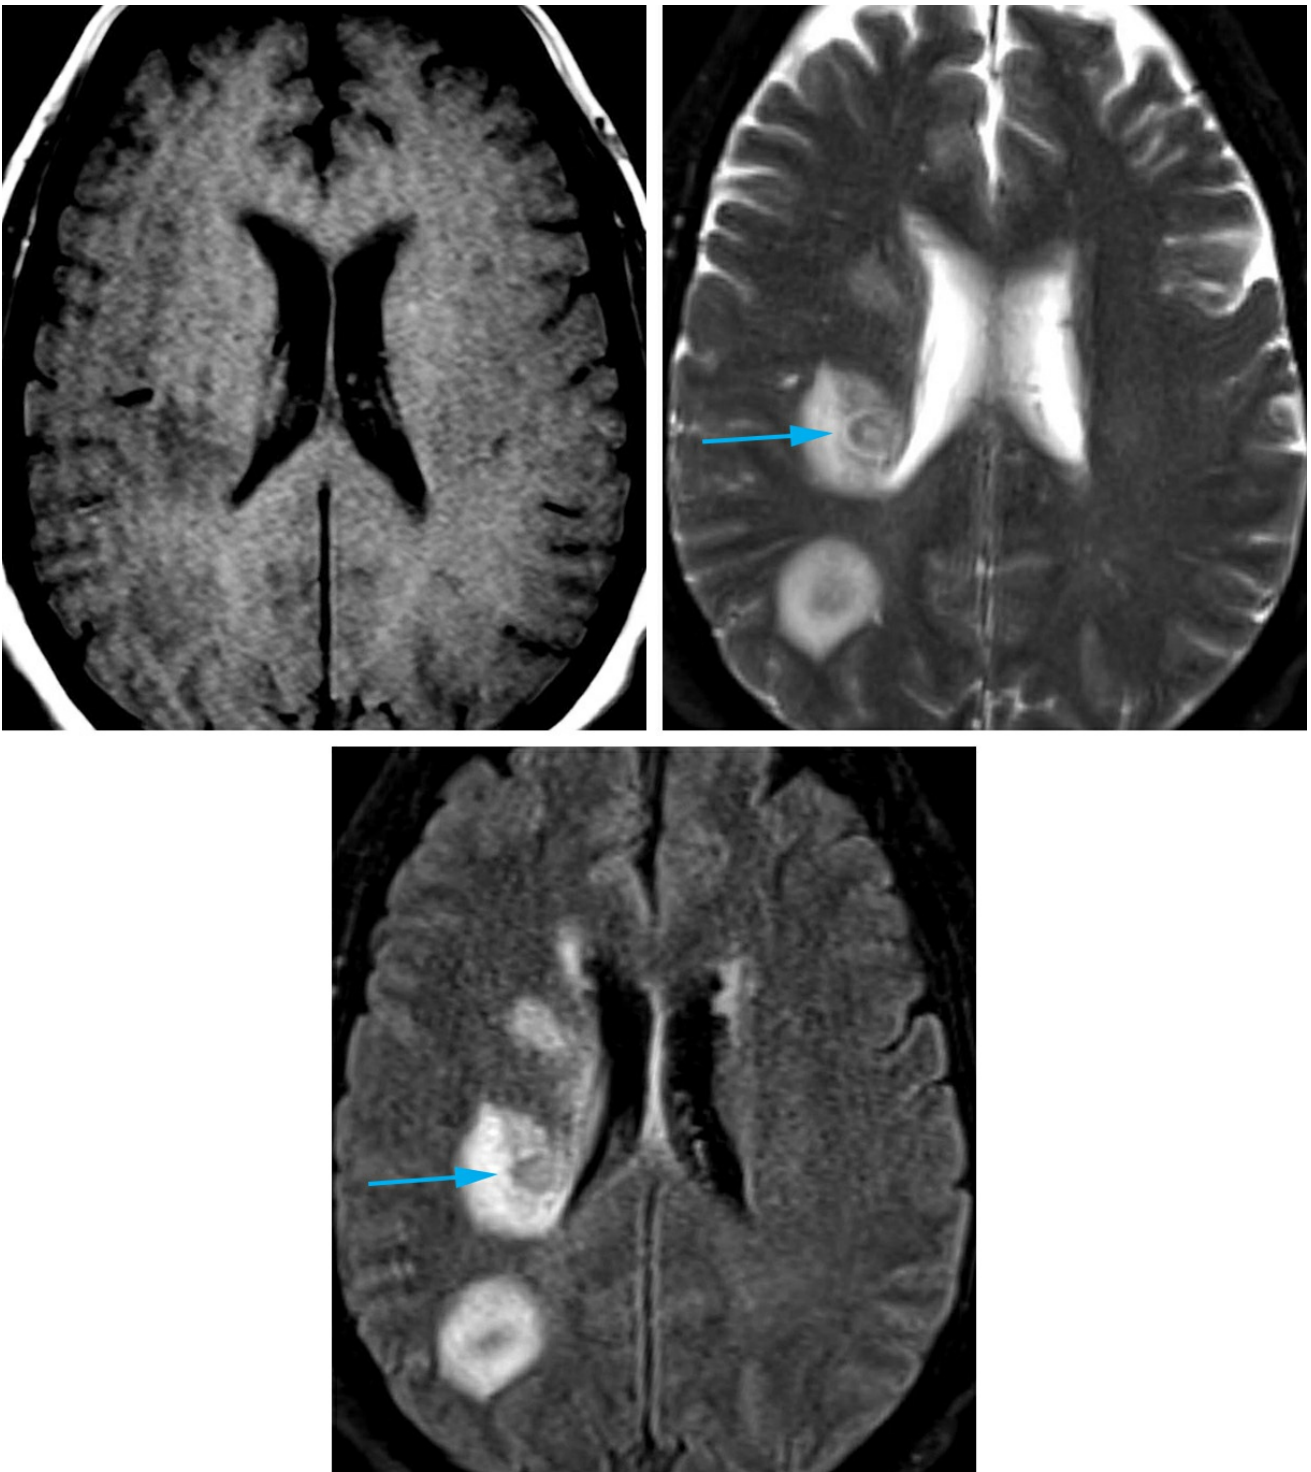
T1 – hypointense anterior lesion, isointense posterior lesion (top row left). T2 and FLAIR – Perilesional bright signal reflecting vasogenic edema (top row right). A discrete capsule with dual hyperintense and hypointense rim is sometimes visible (bottom row, arrows).
